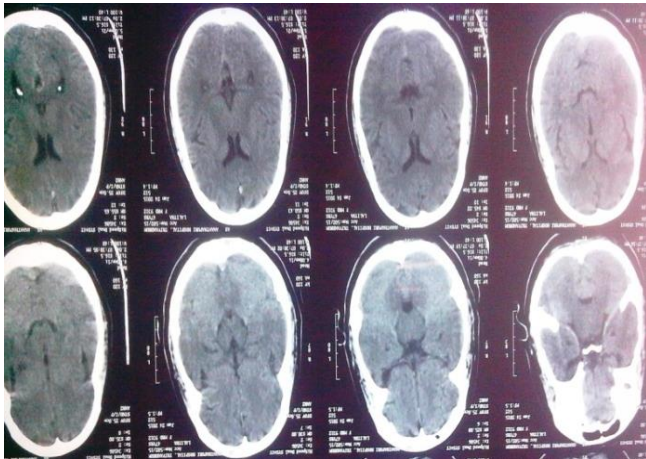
Plain CT brain appears normal
